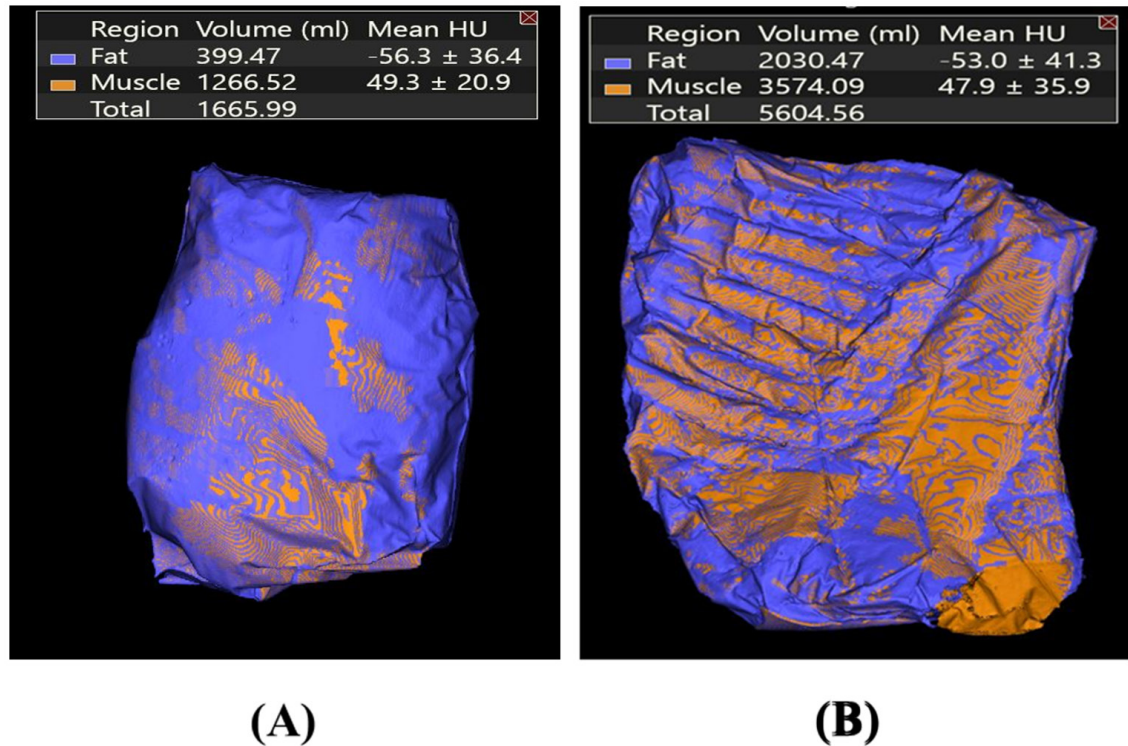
Example of muscle and fat volume in CT (computed tomography) images of (A) pork shoulder butt and (B) belly analyzed by Vitrea workstation version 7 (blue, fat; orange, muscle). HU, Hounsfield units.
